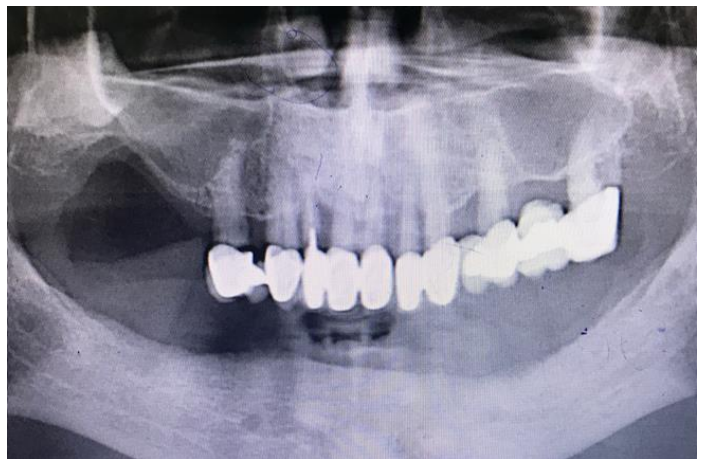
Panoramic radiography image at 36 months follow-up. Regular borders of the right maxillary sinus are observed.
